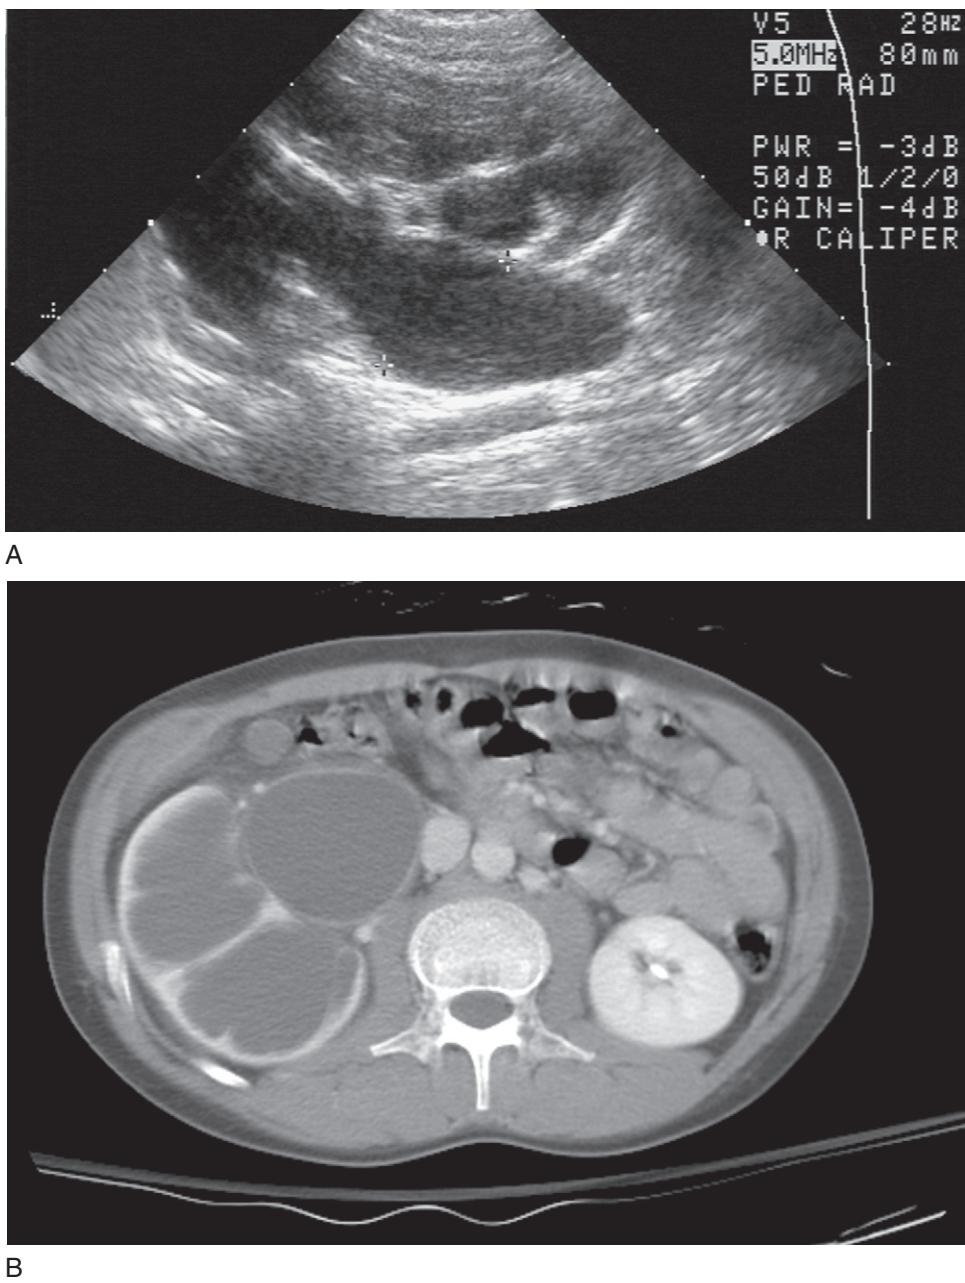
A*, Preoperative ultrasound. *B*, Computed tomography scan.
